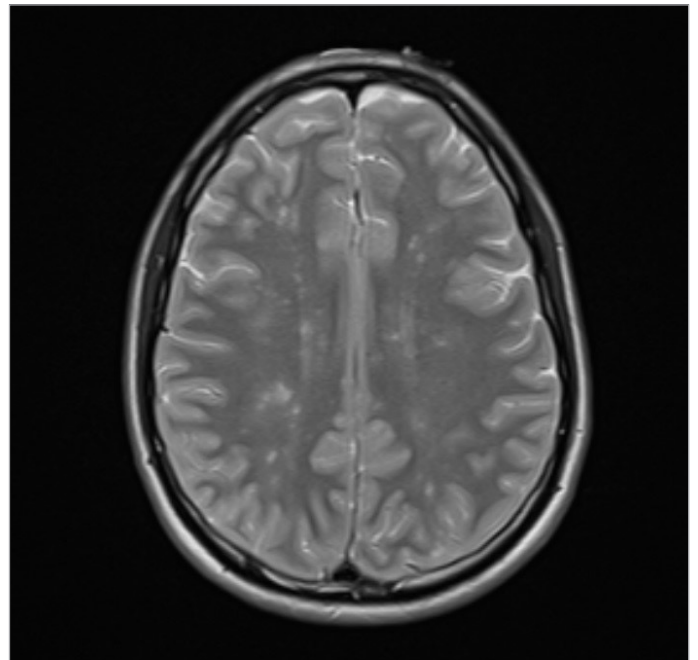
Image of the lesions in the MRI.
